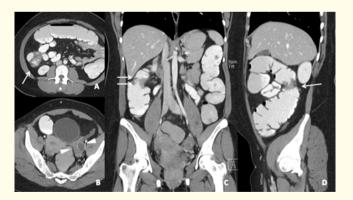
Ascending colon shows a circumferential wall thickening with mild extra serosal irregularities (arrows) denoting T3 lesion radiologically (a, c, d) on CT abdomen. Left ovary appears heterogeneous (b) (arrowheads).
